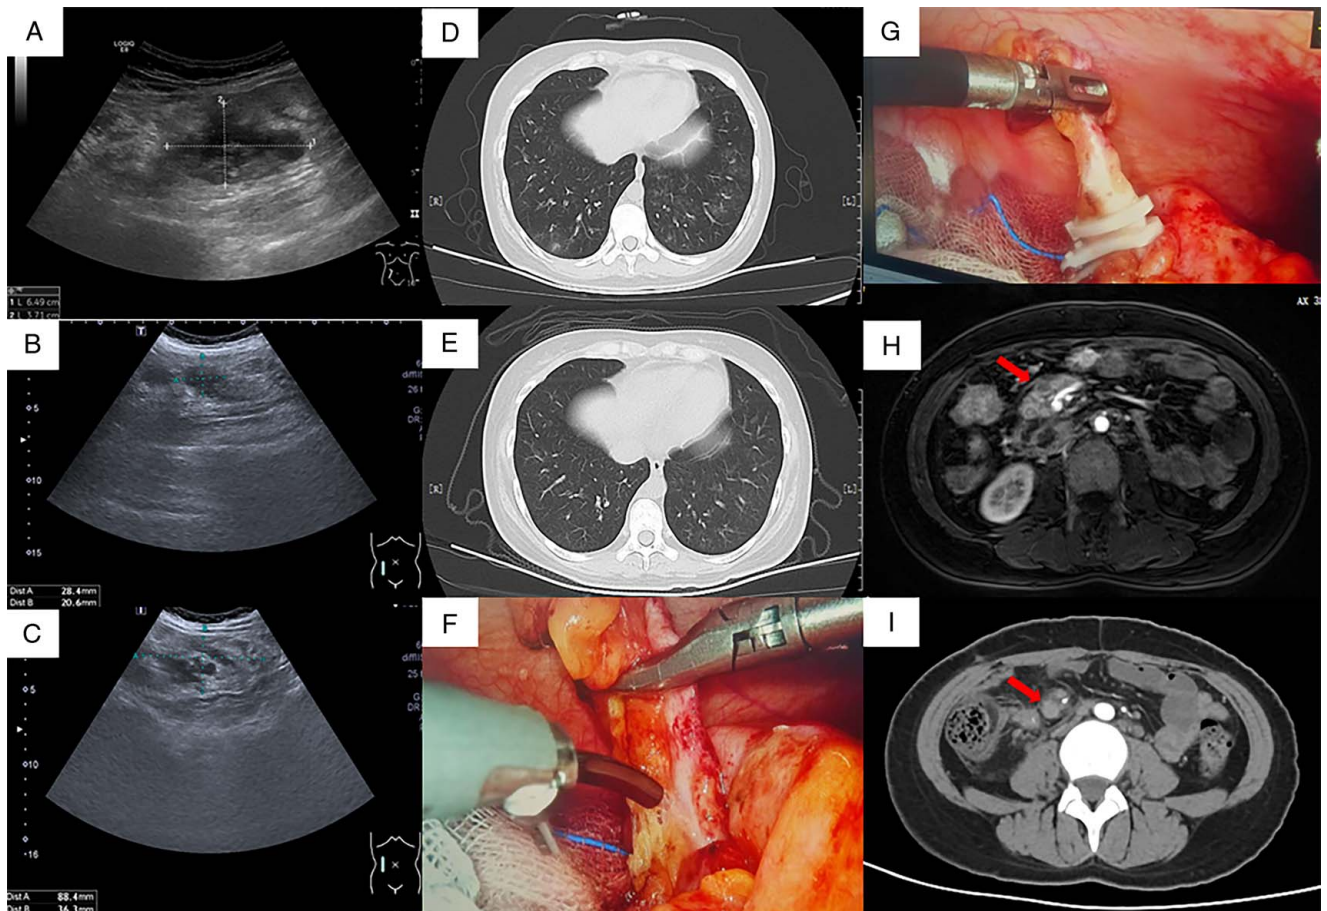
A is the ultrasound findings of the patient on admission, B is after antibiotic treatment and C is after infection with COVID-19. D is CT of the chest with COVID-19 infection, and E is after treatment. F, G. The patient is undergoing a laparoscopic appendectomy. H is the upper abdominal MRI before anti-TB treatment, and I is after anti-TB treatment, showing a significant reduction in the extent of the lesion (red arrow).
